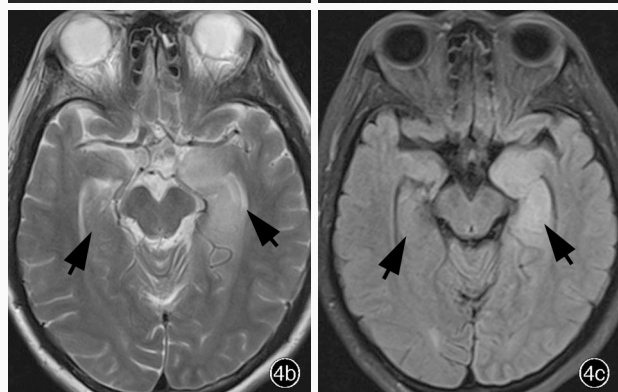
Male patient, 52 years old, clinical diagnosis as anti-LG11 antibody-associated limbic encephalitis. Brain MRI findings Axial contrast-enhanced T₁WI showed slightly swelling of bilateral temporal hippocampus and symmetrical low-intensity signals without enhancement (arrows indicate, Panel 3a). Axial T₂WI showed slightly swelling of bilateral temporal hippocampus with symmetrical high-intensity signals (arrows indicate, Panel 3b). Axial FLAIR showed lesions with high-intensity signals (arrows indicate, Panel 3c). Figure 4 Female patient, 52 years old, clinical diagnosis as anti-LG11 antibody-associated limbic encephalitis. Brain MRI findings Axial T₁WI showed slightly swelling of left medial temporal hippocampus with low-intensity signals (arrows indicate, Panel 4a). Axial T₂WI showed slightly swelling of left medial temporal hippocampus with high-intensity signals (arrows indicate, Panel 4b). Axial FLAIR showed lesions with high-intensity signals (arrows indicate, Panel 4c).
